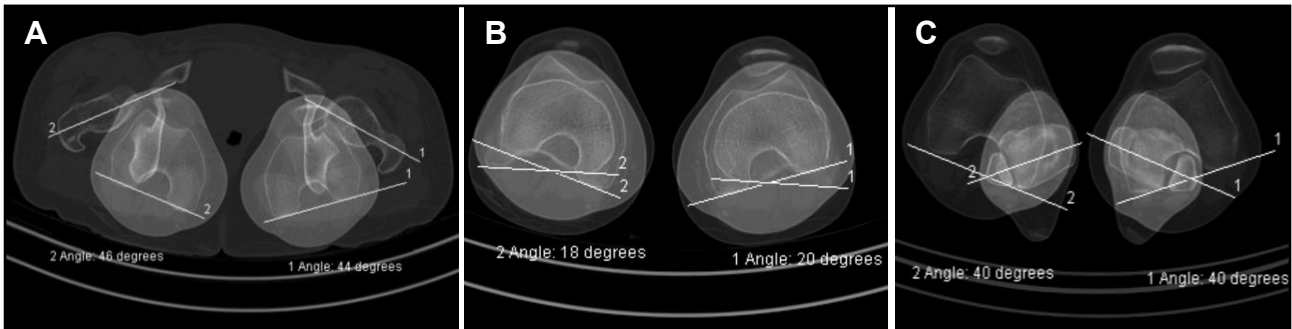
CT with lower limb rotational assessment. (A) Femoral neck anteversion (right side: 46°; left side: 44°). (B) Femoro-tibial rotation (right side: 18°; left side: 20°). (C) Tibial external torsion (right side: 40°; left side: 40°).
